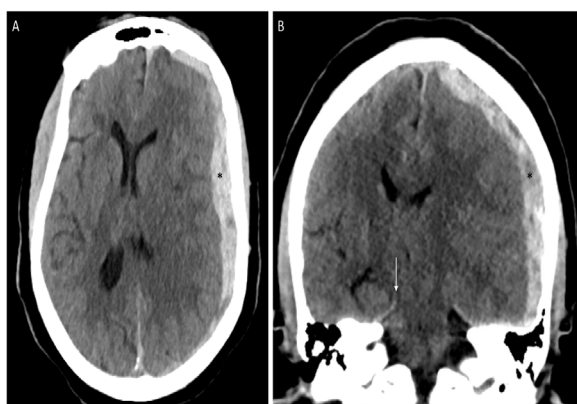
Axial (A) and coronal (B) CT of the head demonstrates an acute left-sided subdural hematoma (asterisk) with midline shift and compression of the contralateral cerebral peduncle against the free edge of the tentorium (arrow).
